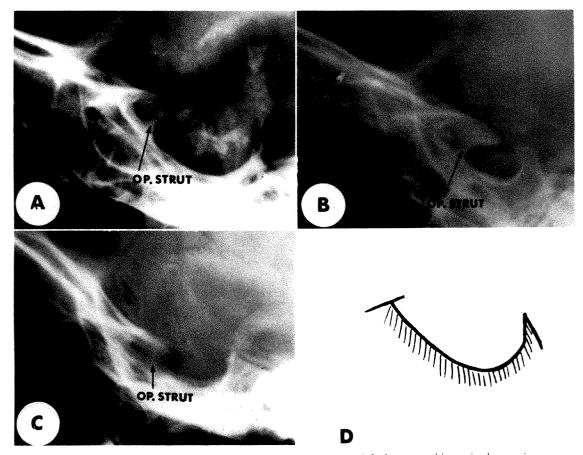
The optic strut in abnormal lateral skull roentgenograms. (A) A 7 year old craniopharyngioma case. (B) A 5 year old craniopharyngioma case. (C) An 8 year old case with a parasellar subarachnoid cyst. Note the clear visualization of the optic strut in these cases. This phenomenon is only possible in the presence of tuberculum sellae and chiasmatic sulcus flattening or erosion. It is not present in normal cases. The optic strut should not be mistaken for the tuberculum sellae thus implying a lesser destructive process than is actually present. (D) Tracing of case in A demonstrating absence of the anterior sellar wall.
